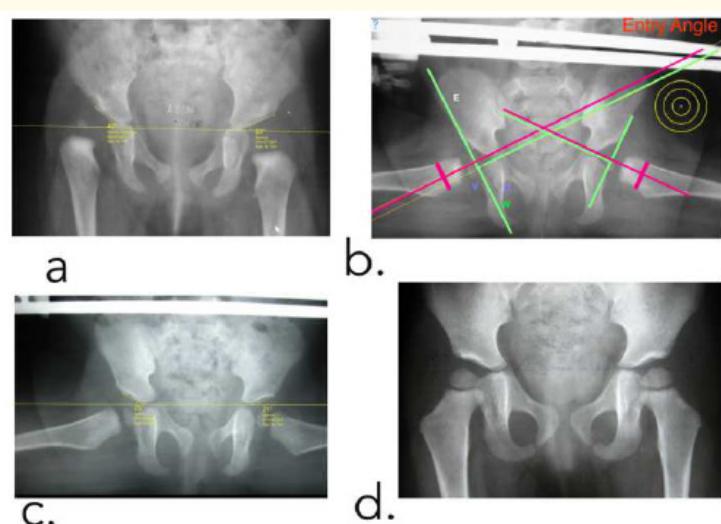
a. Anteroposterior radiograph of the pelvis of a six month-old girl with unilateral Tönnis grade-III hip dislocation. Initial X-rays measure an Acetabular Index of 40 degrees. Complete reduction after two months (phase A). b. Starting phase B with abduction splint. Entry angle is zero on X-ray. c. Anteroposterior radiograph, five months later, Acetabular Index now 25 degrees showing that the acetabulum has strongly remodeled. Notice and compare the improvement in the acetabular index. d. Anteroposterior radiograph, 21 months later, showing that the acetabulum has remodeled completely and the femoral head is spherical and concentric.
